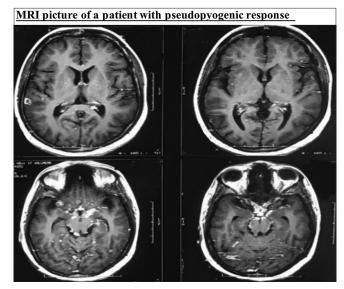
T1 contrast magnetic resonance imaging axial section showing multiple tuberculomas with basal exudates and meningeal enhancement in a 38-year-old female with a history of fever and headache for 1 month with highly probable Stage 2 TBM on day 35 of illness, cerebrospinal fluid cells 2400/mm³ with 84% polymorphs, and protein 174 sugar 20. At 3-month, the patient had good outcome (modified Rankin scale 0).
